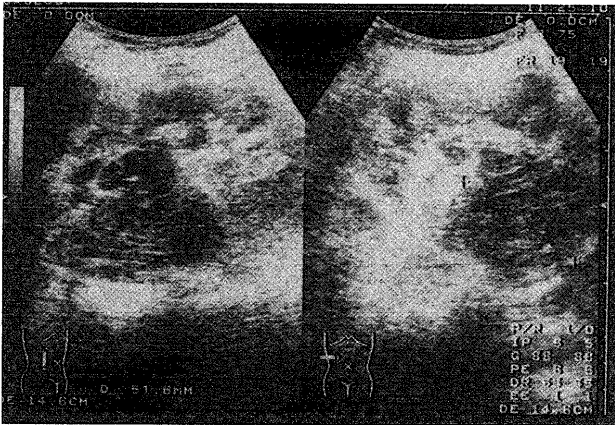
Abdominal ultrasonography shows a mass of the right kidney.
